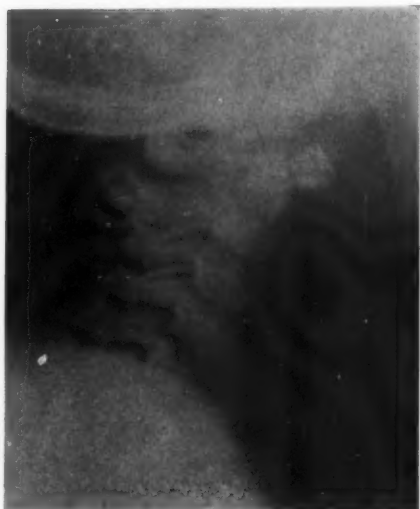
Lateral roentgenogram of neck. Note air in esophagus, outlining the subglottic obstruction.
